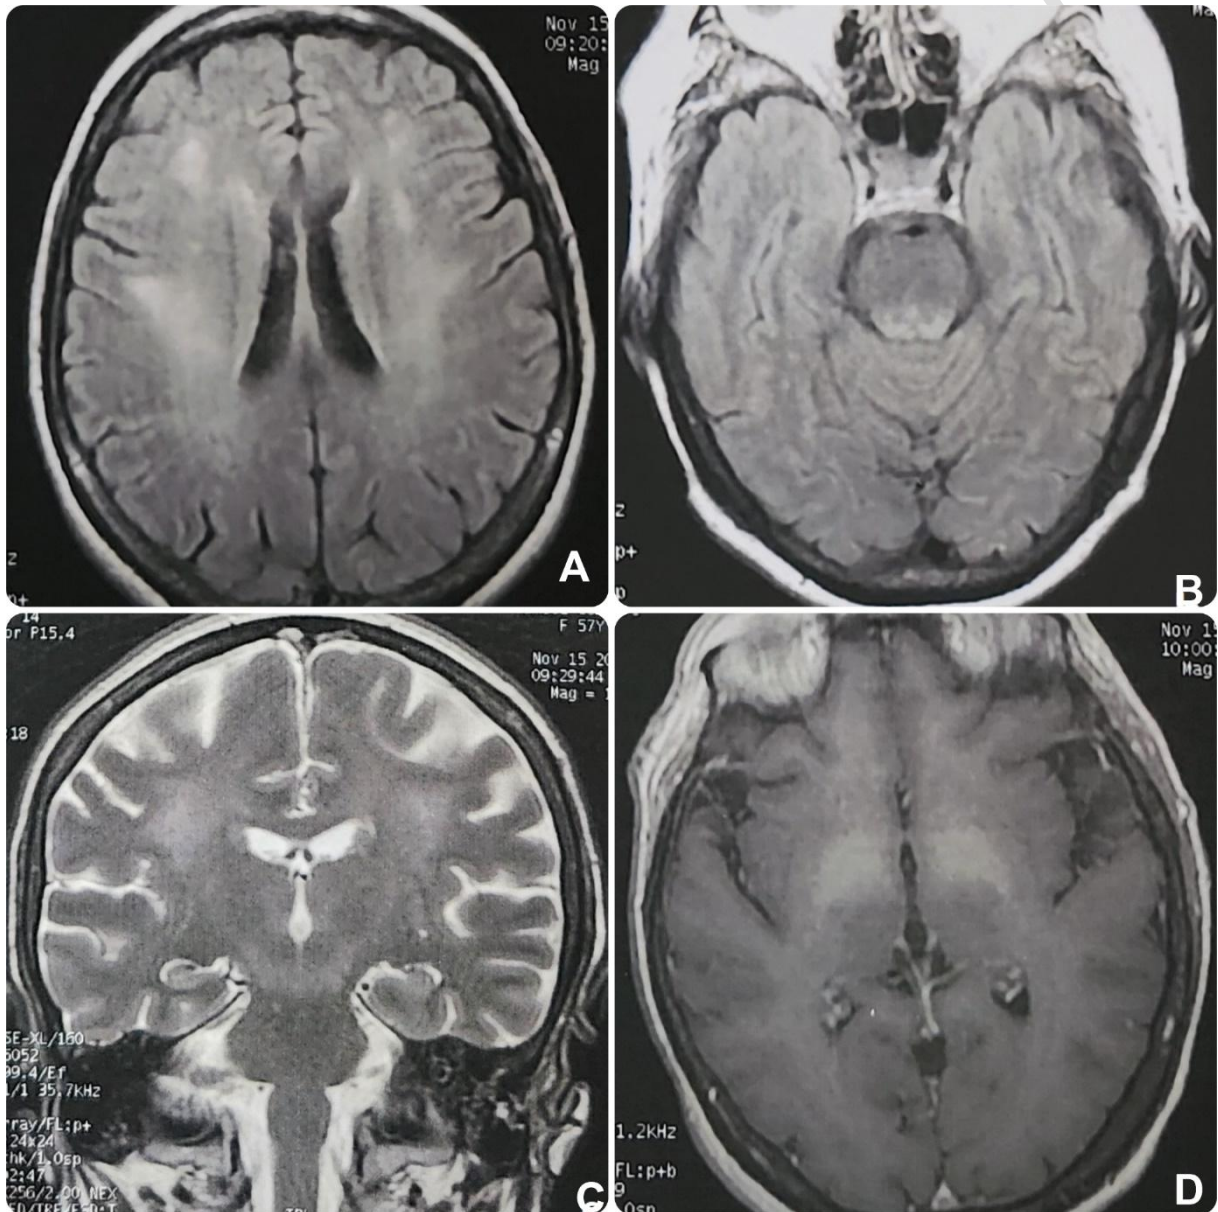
Cerebral MRI in axial T2 FLAIR (A,B) and in coronal T2 (C) showing periventricular and periaqueductal white matter hyperintensities. Axial T1 sequence (D) showing bilateral pallidal hyperintensity.
